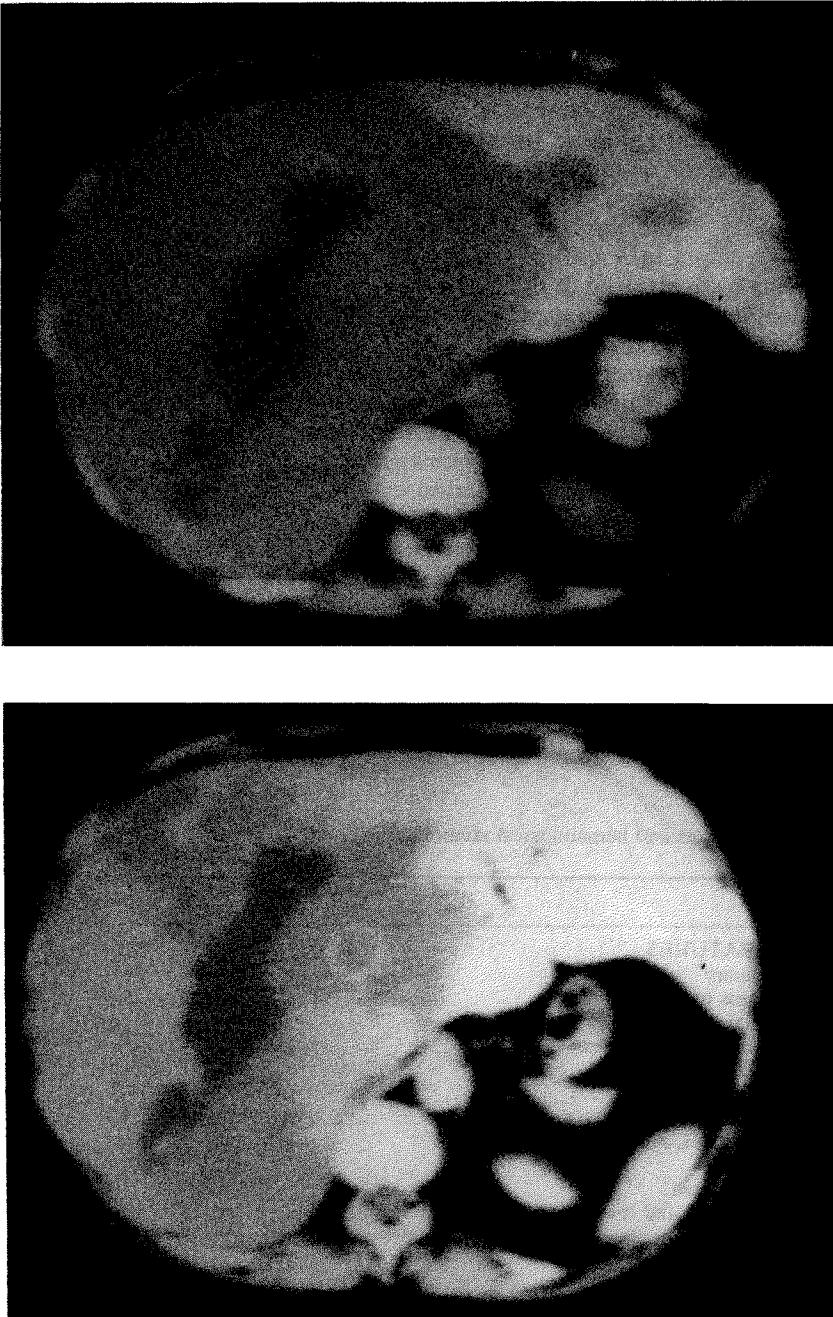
(a). Plain CT scan (Case 15) showing huge hemangioma of right lobe liver with large central blood filled cavity. (b) Early phase of dense contrast accumulation after IV bolous injection.
